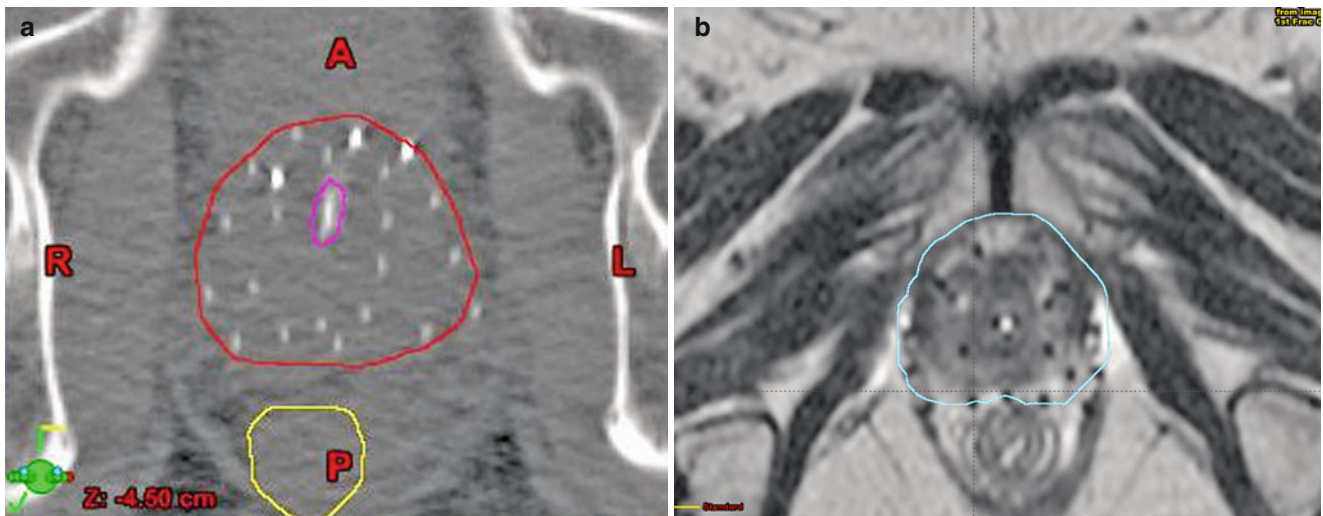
Acquisition of images with the catheters in place: (a) CT-scan based, (b) MRI-scan based
